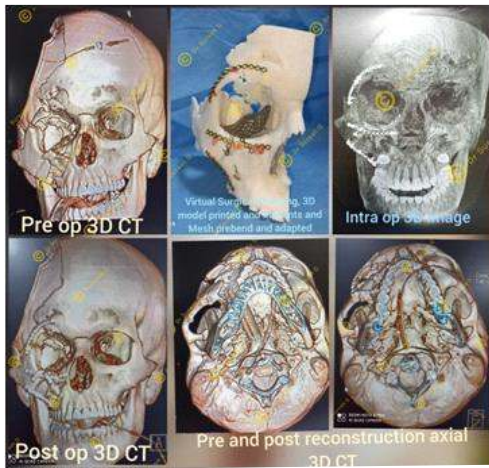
3D CT images Pre op, Intra op, and Post op.
